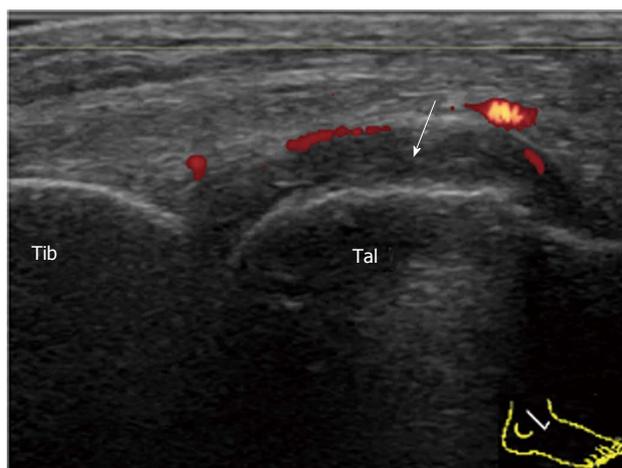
Synovial proliferation in rheumatoid arthritis. Sagittal power Doppler sonogram of the lateral side of the anterior recess of the tibiotalar joint shows synovial thickening (arrow) with peripheral vascularization. Tib: Tibia; Tal: Talus.
